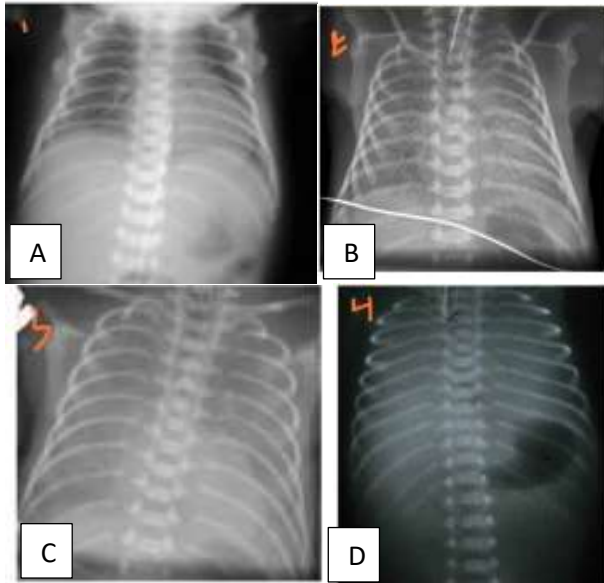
Grades of RDS on chest X-ray. (A) grade I, (B) grade II, (C) grade III, (D) grade IV.
